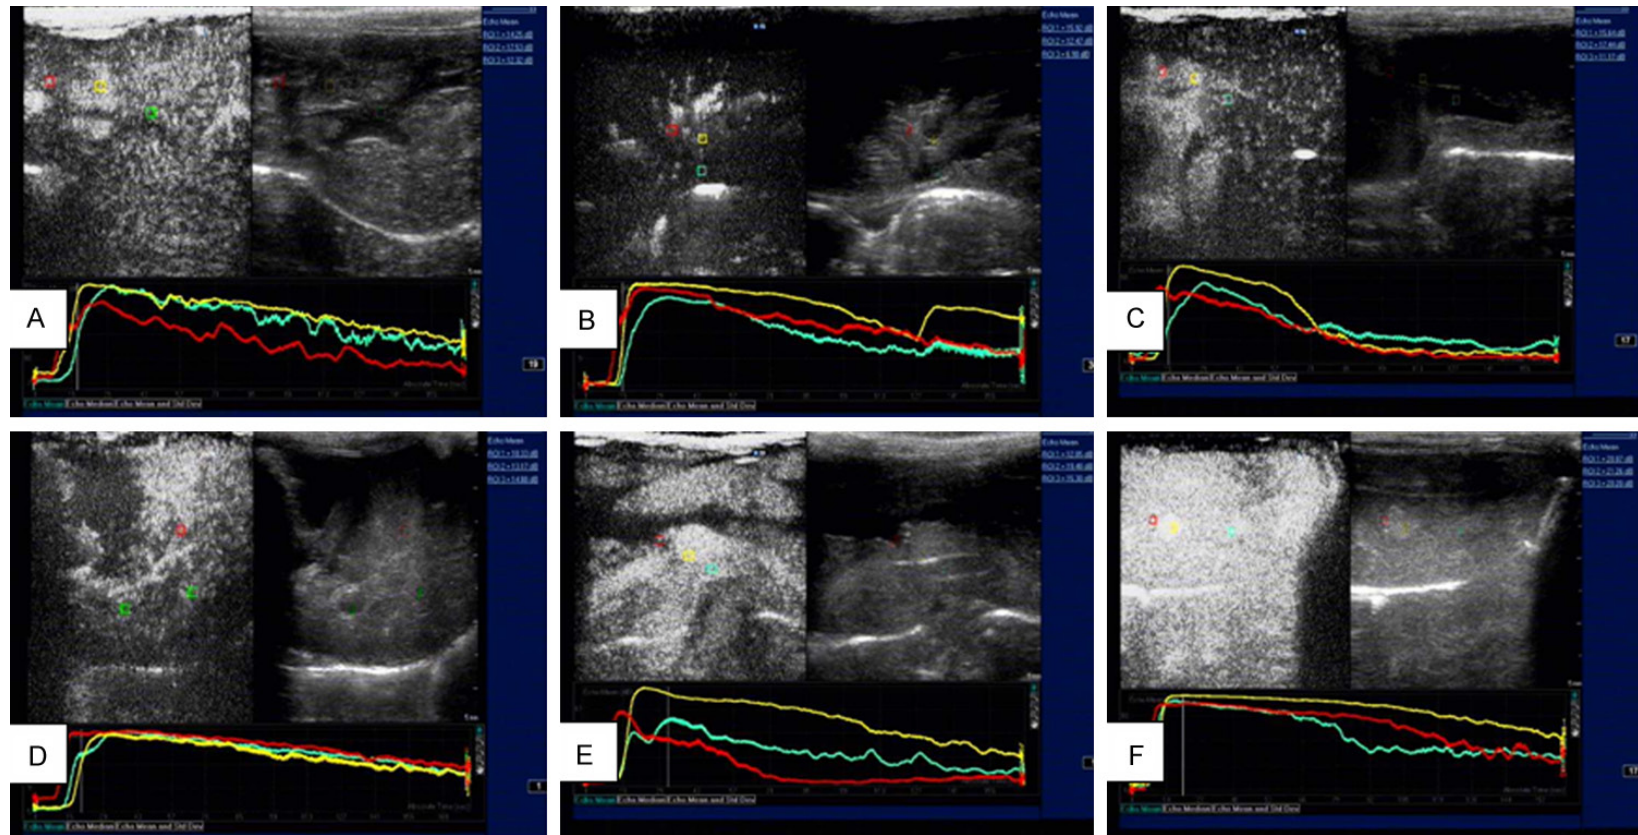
Time-intensity curve after infusion of ultrasound contrast of CEUS. Red: hepatic artery; yellow: portal vein; green: hepatic vein. A: Control group; B: S0 group; C: S1 group; D: S2 group; E: S3 group; F: S4 group.
